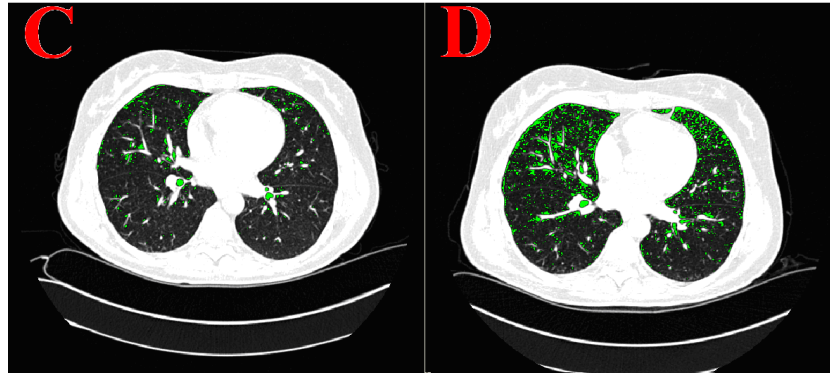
Transverse CT scans from a participant who stopped smoking between baseline (C) visit and 1 year follow-up (D). Slice position and inspiration level was similar in the images (Δ CT volume = 0.08 L). Green areas highlight areas with lung density below -950 HU. Smoking cessation revealed more low attenuation areas at follow-up.
